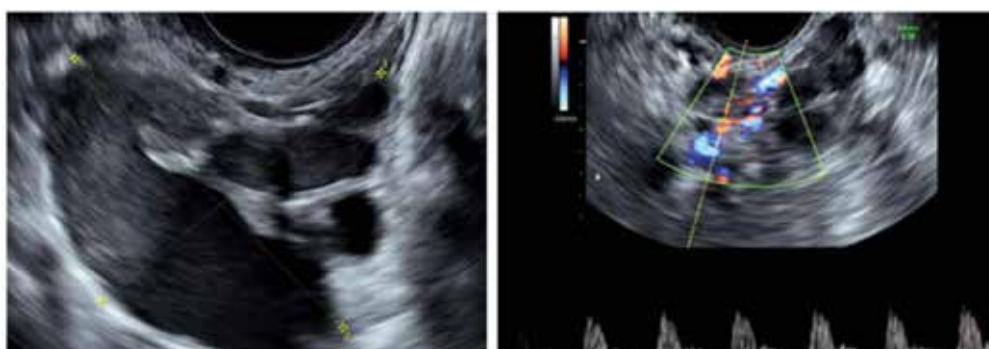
Ultrasonographic images of fallopian tube endometriosis showing a dilated tube with thick walls, incomplete septa, and dense liquid content.<sup>25</sup>
